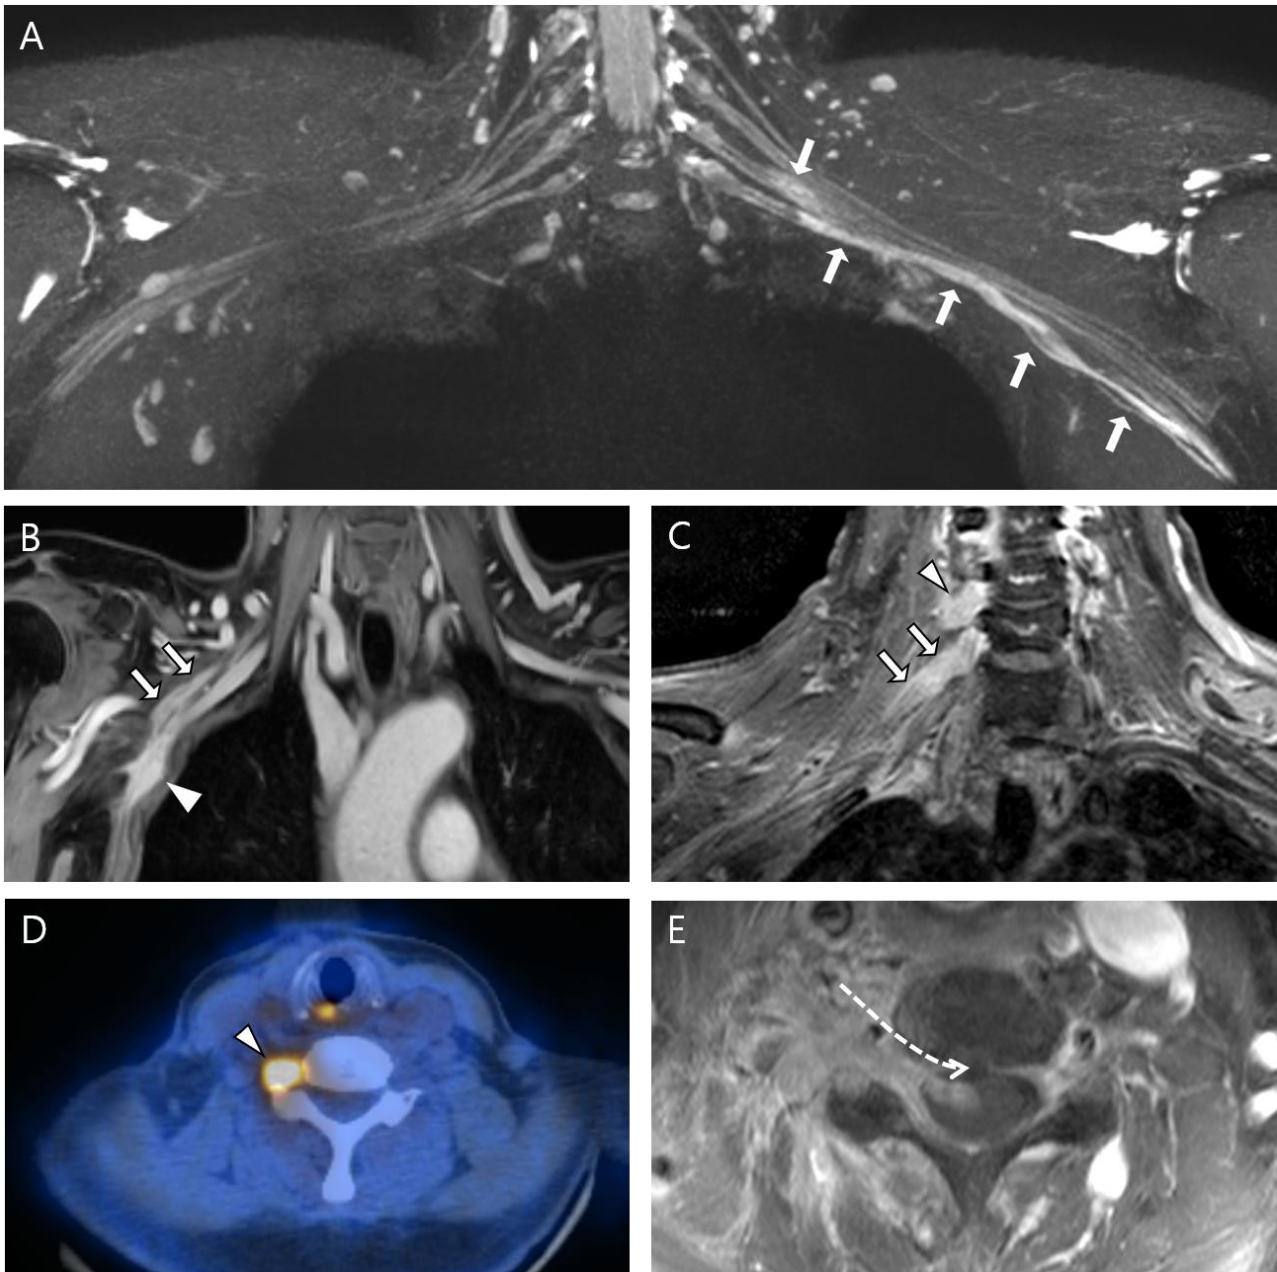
(A) Coronal maximum intensity projection reconstruction images based on T2-weighted imaging of the brachial plexus MRI of patient #3 showed diffuse enlargement and increased T2 signal intensity from the distal C7 and C8 roots to the distal branches of the brachial plexus (arrow). (B) The coronal T1 fat-saturated (FS) gadolinium-enhanced brachial plexus MRI of patient #6 demonstrated a recurrent tumor at the right chest wall (arrowhead) and noted enhancement of the medial cord and lower trunk (arrow). (C) Seven months after the diagnosis of perineural spread in patient #5, a coronal T1 FS enhanced brachial plexus MRI image demonstrated further perineural spreading to the right C6 and C7 spinal nerve roots (arrow), and (D) increased uptake of the right C6 nerve root was noted on an F18-FDG PET-CT scan. (E) Sixteen months after the diagnosis of perineural spread in patient #5, a follow-up cervical spine MRI T1 FS axial post-gadolinium image depicted intradural extension at the C4-5 level.
